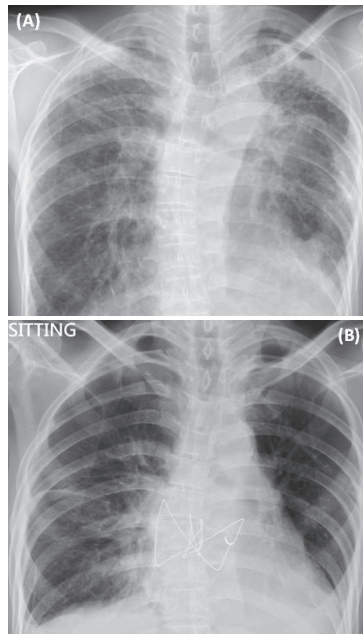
Pre- and post-transplant Chest X-ray. (A) 1 month before lung transplants: bilateral pleural thickening and fibrosis, bilateral upper lobes most markedly; volume reduction of the left lung. (B) 11 months after bilateral lung transplants.
